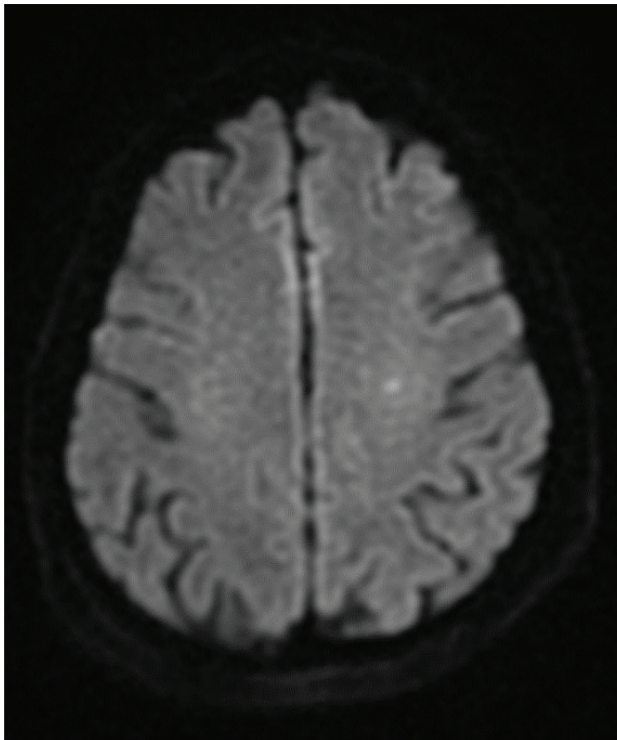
Non-enhanced brain MRI visualizing late subacute infarction in the territory of the left anterior cerebral artery—small foci with high DWI signal and moderate to low corresponding ADC map.
